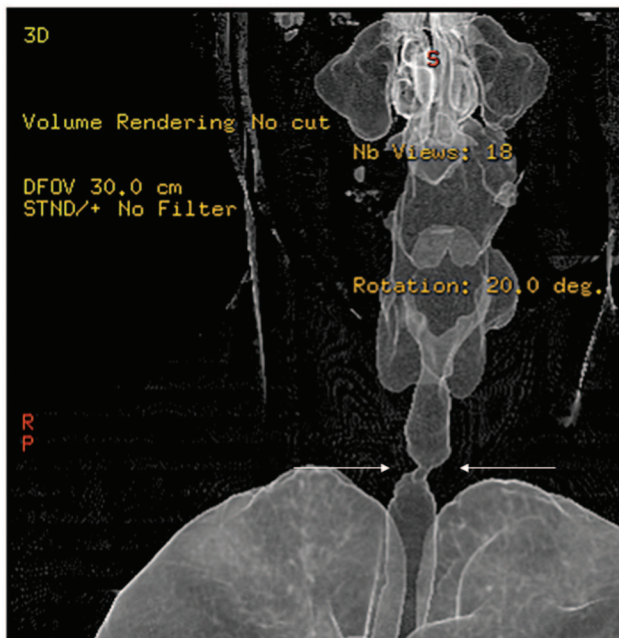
Three-dimensional computed tomogram shows stenosis of the upper trachea (arrows).
